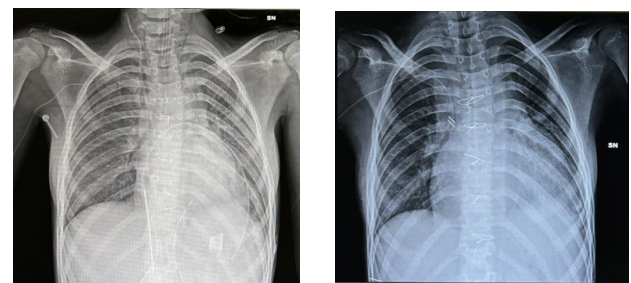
Comparison of T0-T1 chest x-rays.
